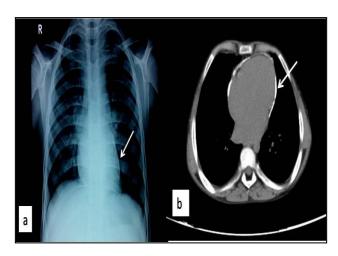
Chest X-ray PA view a) Computed tomography chest b) demonstrating the pericardial calcification (arrow in a and b).
